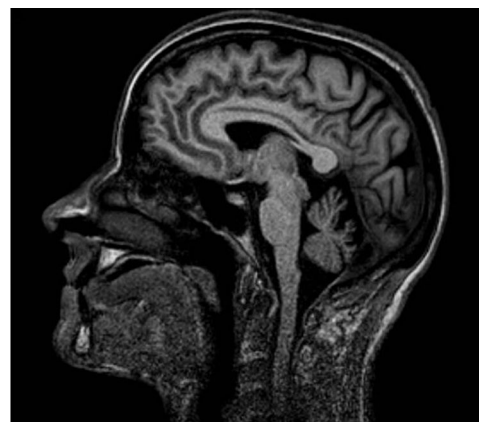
T1-weighted sagittal brain MRI scan showing cerebellar atrophy.
